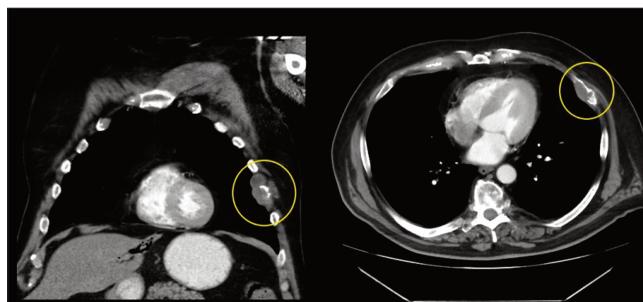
CT scan chest with contrast showing a soft tissue mass involving left sided sixth rib extending into 5th and 6th intercostal space (Coronal & Axial view).
